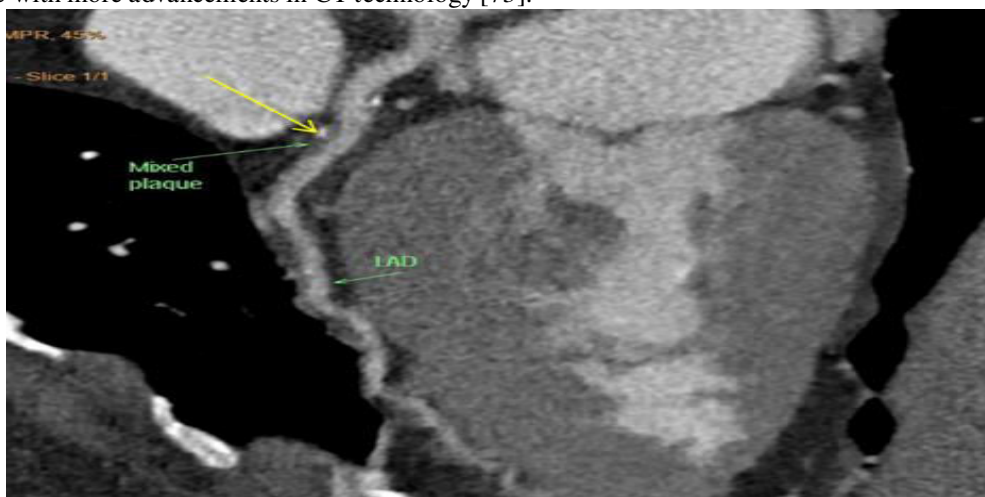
MDCT curved multiplanar reconstruction of the left anterior descending artery [LAD] showed a mixed atherosclerotic plaque with spotty calcification in the proximal segment on coronary CTA [yellow arrow].
